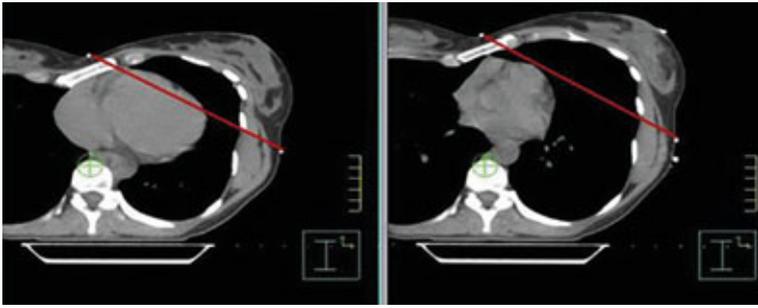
Heart position on axial CT slices of the same patient with breast cancer at free-breathing (left) and deep-inspiration breath-hold (DIBH) (right). The red line indicates the tangential treatment field border for whole-breast irradiation (WBI). With permission.⁷⁵
